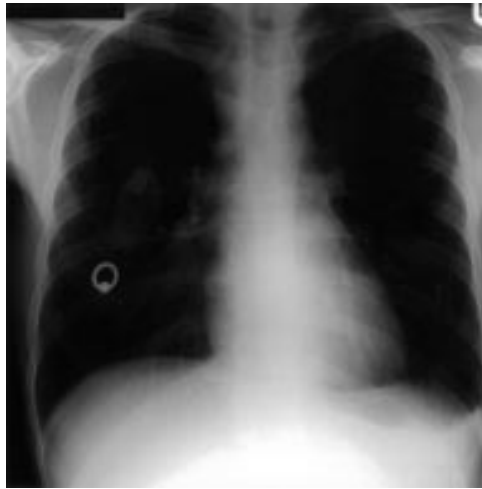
Chest radiograph on day 19 of admission. The lung fields have cleared but there is persistent lymphadenopathy.
